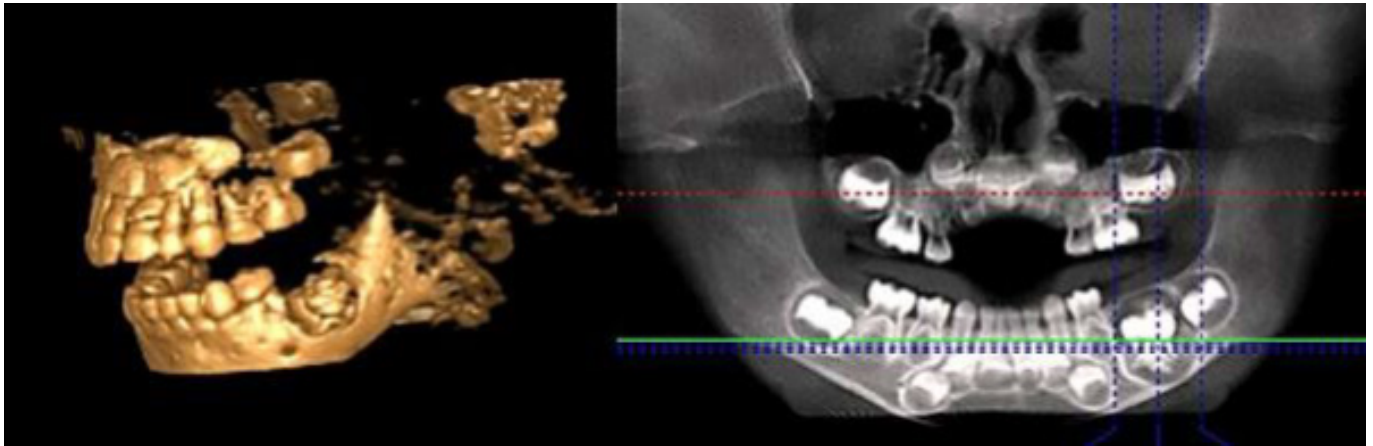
Data from the CBCT study of a 3-year-old patient; diagnosis of a complex mandibular odontoma on the left
